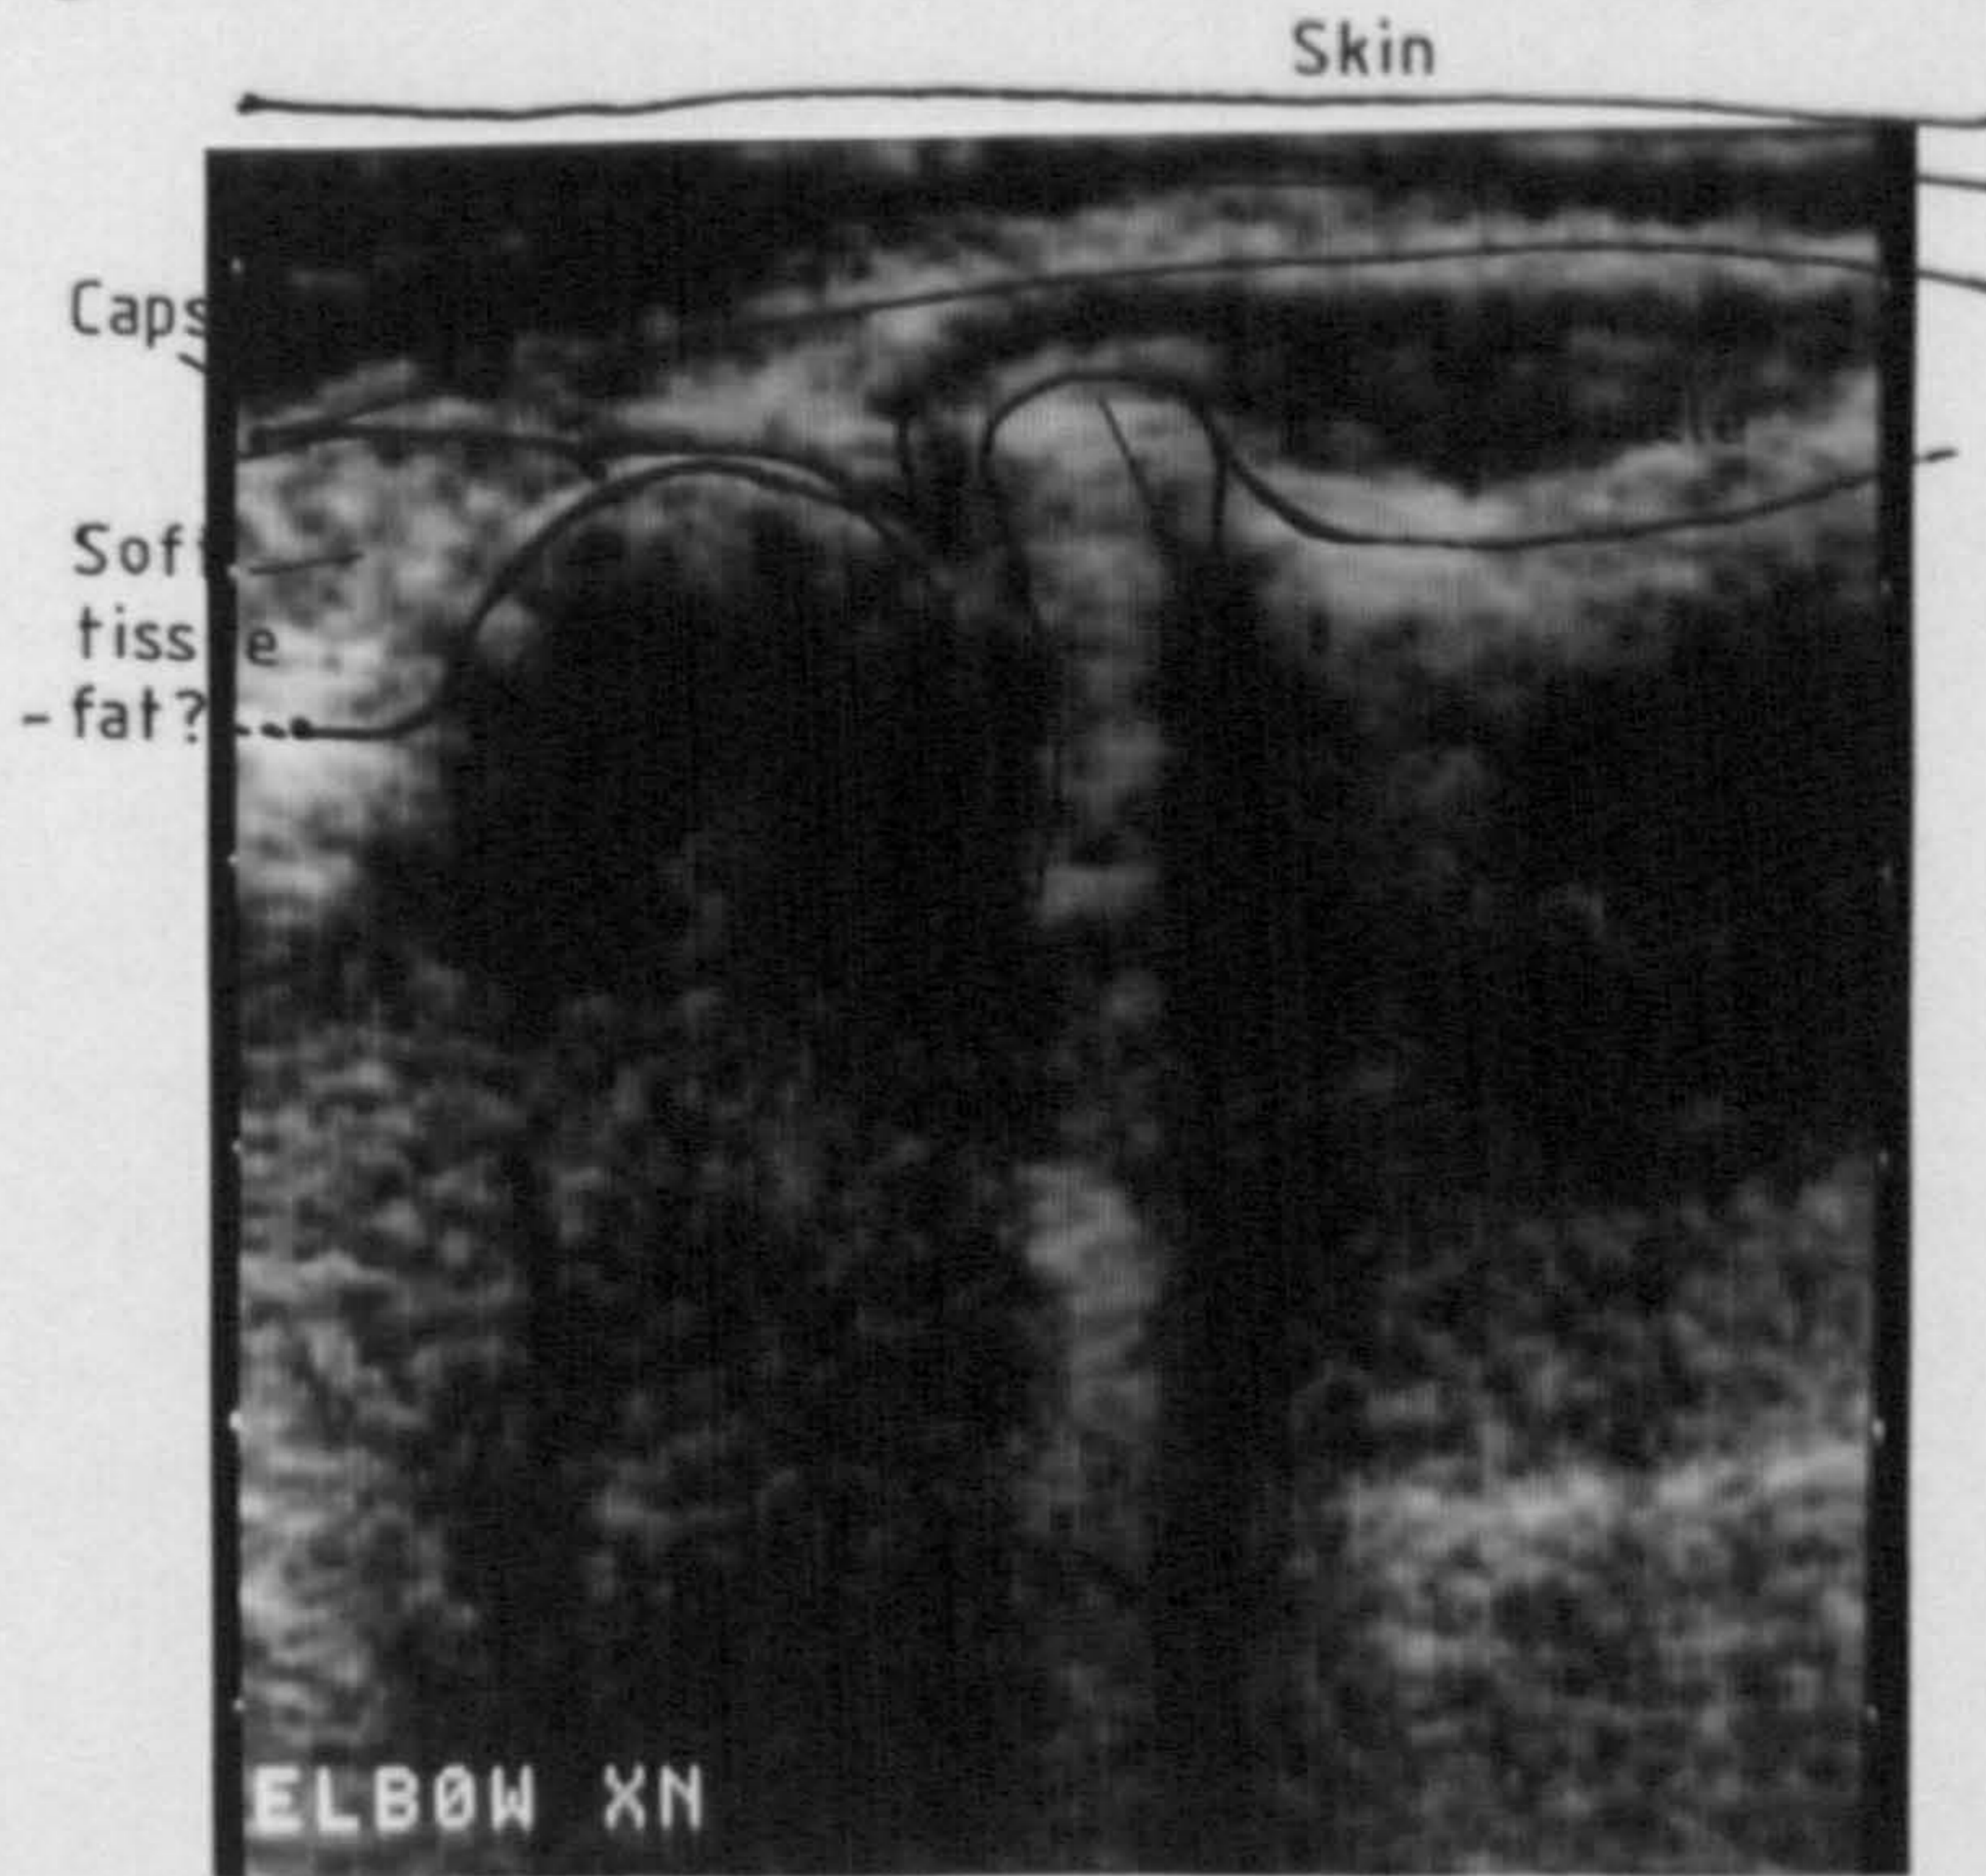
b Ultrasound scan right elbow
